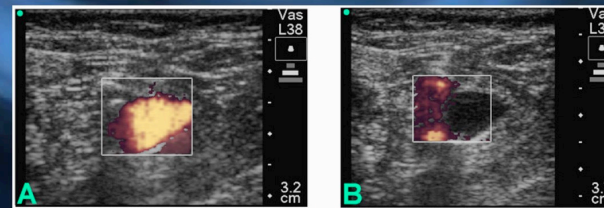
Short axis (transverse) duplex images of femoral vessels at the location clinicians typically choose for venipuncture and cannulation. (A) Flow within superficial femoral vein. (B) Flow within superficial and deep femoral arteries. By injecting the iliacs, the instructor mimics in-vivo blood flow as perceived on color power doppler downstream. Vessel location becomes more conspicuous, enabling easier identification by the student.
